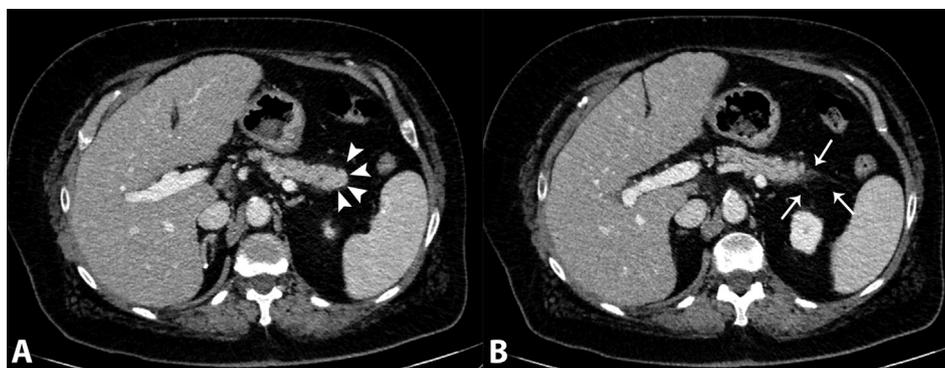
CT scan of our patient showing (A) a loss of the lobulations of the pancreatic tail (arrowheads) and (B) a mild surrounding fat stranding (arrows), characteristics of interstitial oedematous pancreatitis. CT, computed tomography.
